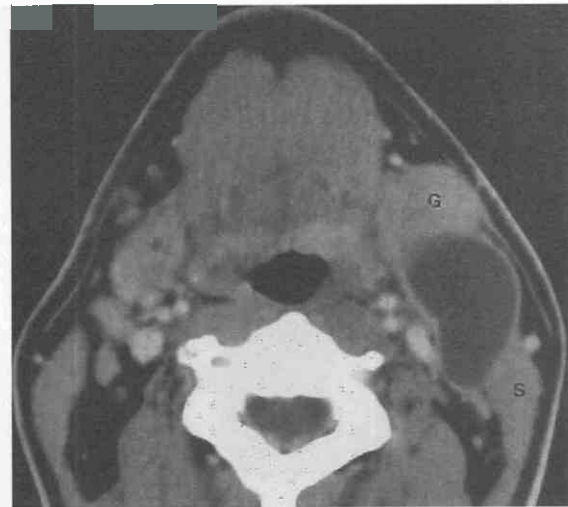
Type II second branchial cleft cyst. Axial contrast-enhanced CT scan demonstrates a unilocular cystic mass with minimal rim enhancement along the anterior margin of the left sternocleidomastoid muscle (s) displacing the left submandibular gland (G) anteriorly.
